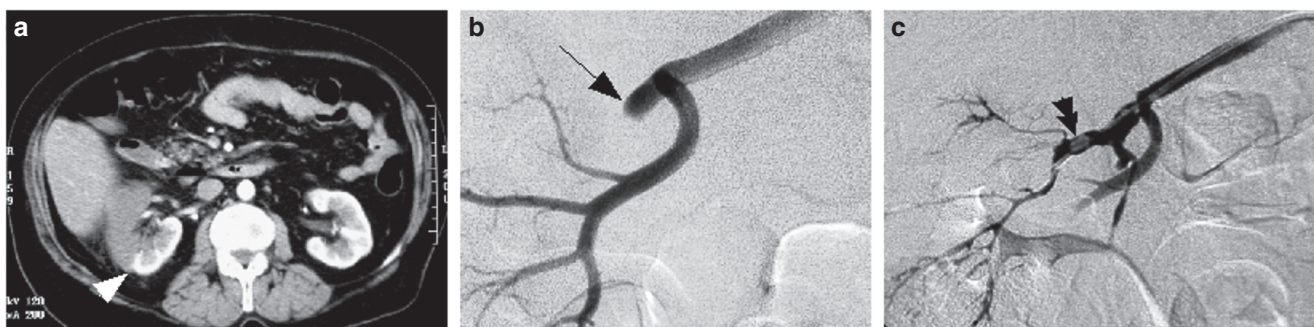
Complete obstruction of the anterior branch of the right renal artery. (a) Contrast-enhanced computed tomography of the hypodense area suggested ventral kidney infarction. The bloodless line (arrowhead) is at the junction of the anterior two-thirds of the kidney and the posterior third part. (b) Arteriogram of the right kidney artery: the anterior branch is completely obstructed (arrow) by a thrombus. (c) After partial removal, the anterior branch is visible and the thrombus is still present (arrowheads).
